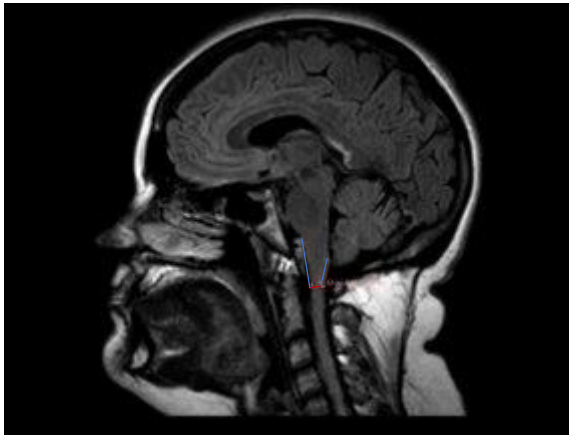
Sagittal FLAIR image and the red line shows the medulla width measure.
